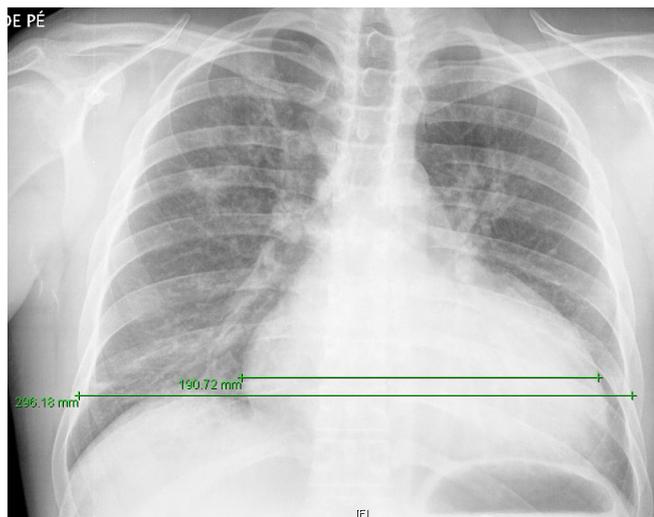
Initial chest X-ray. A posteroanterior chest X-ray view shows cardiomegaly, with a cardiothoracic ratio of 0.64 and mild perihilar congestion.
